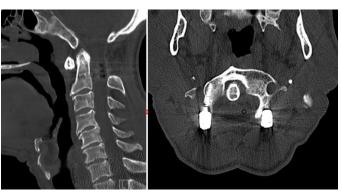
2nd patient post-operative 8th year CT CT: Computed tomography
